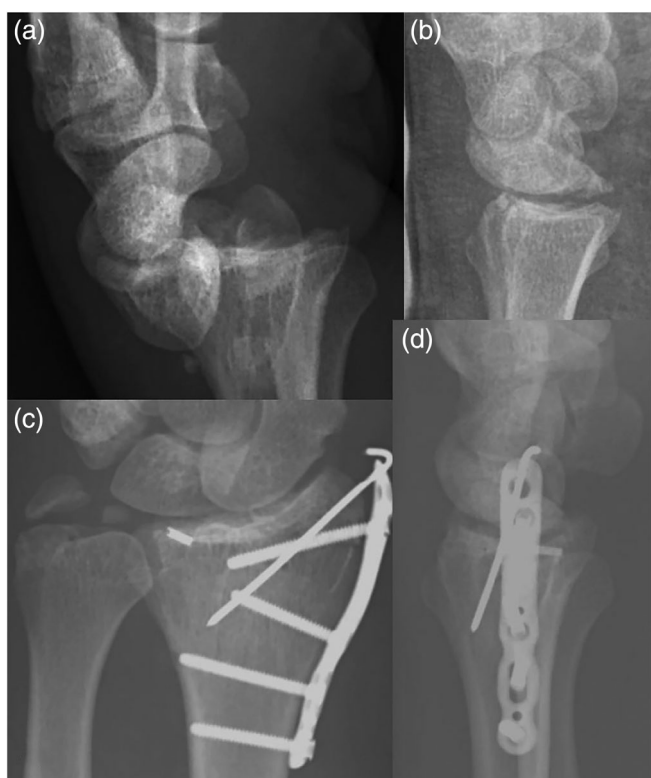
Type IV (a) dislocated and (b) reduced lateral radiograph views of the wrist joint showing small dorsal and small volar fragment (c) PA view post fixation of the radial styloid fracture using a plate and buried k wire. Note the metal anchor in place ulnarly post repair of the SRL. (d) Lateral view showing the metalware and reduced joint. Approach in this case was volar with separate incision for styloid plate.
